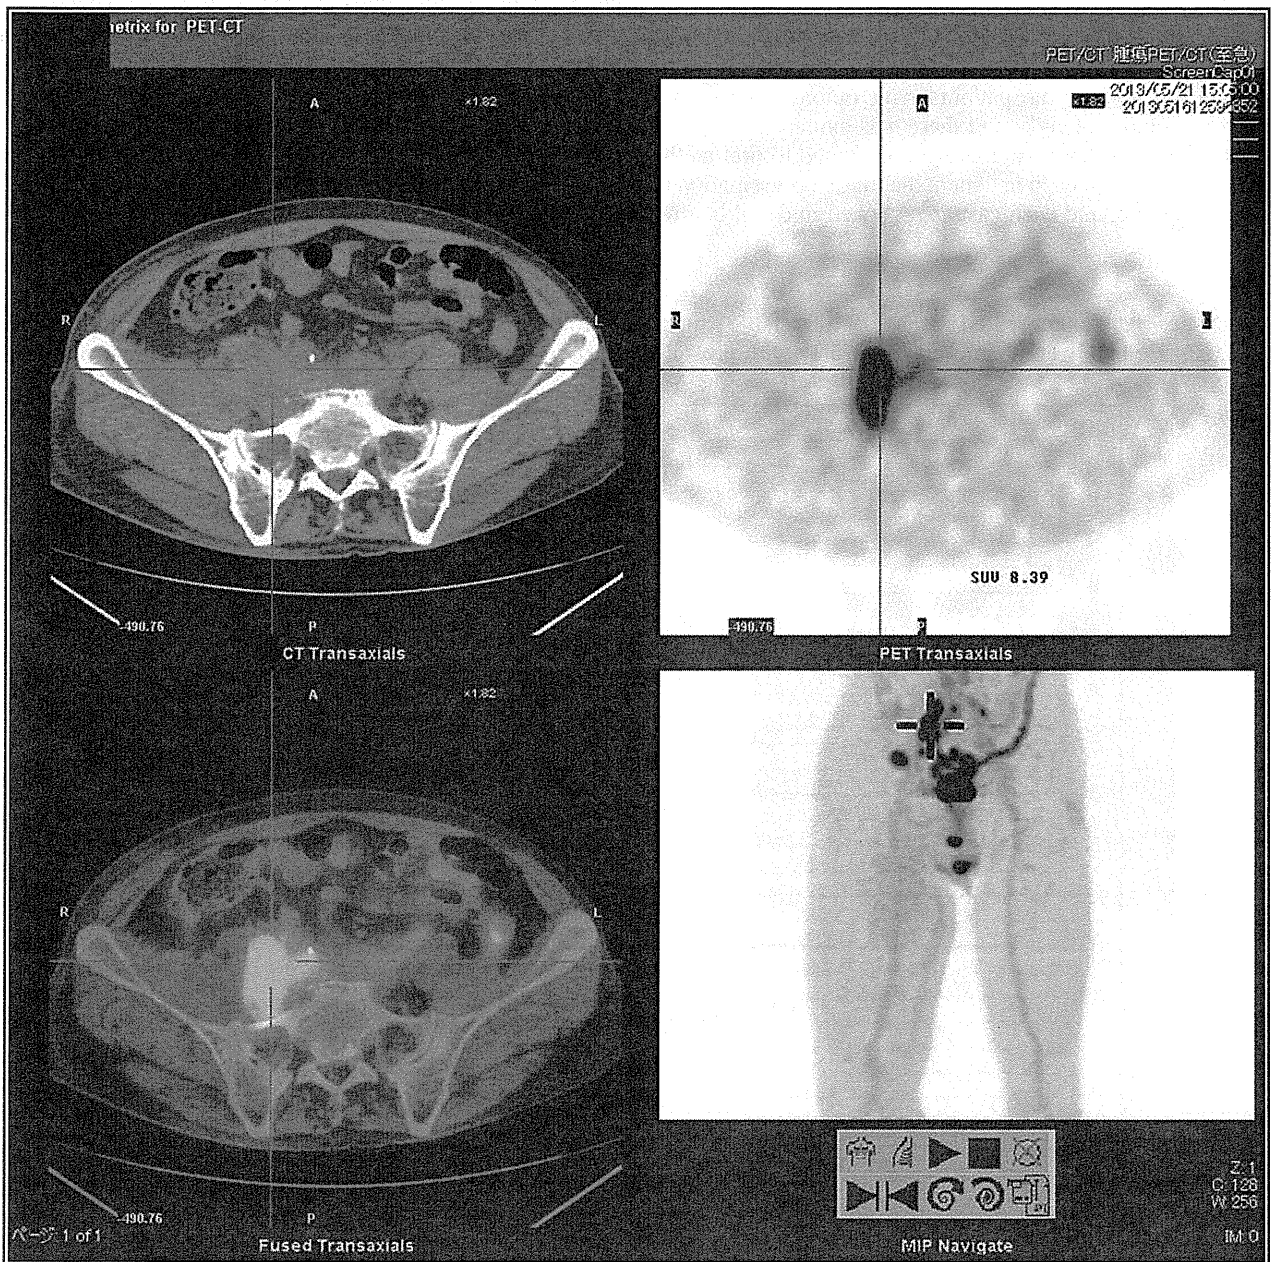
Positron emission tomography/computed tomography of Case 1 on admission.
